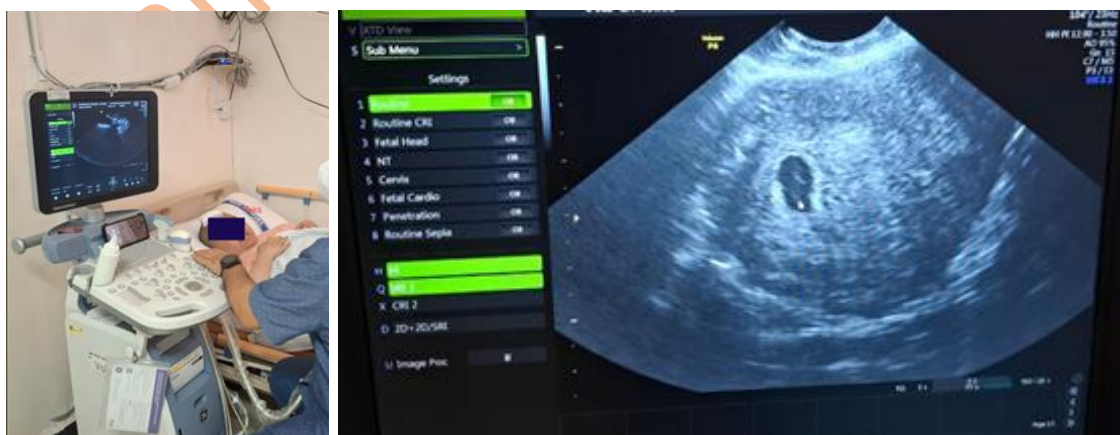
Fetal assessment via ultrasound by an obstetric specialist
